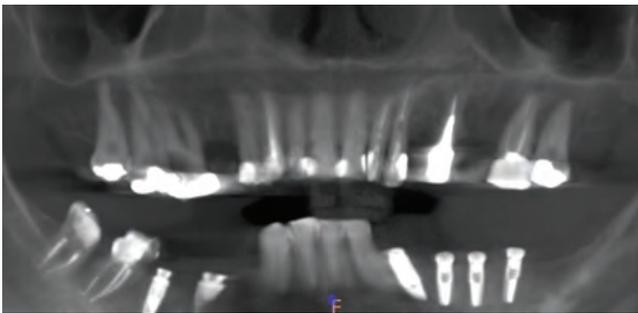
X-ray after 4 months of healing, before the placement of implants.
